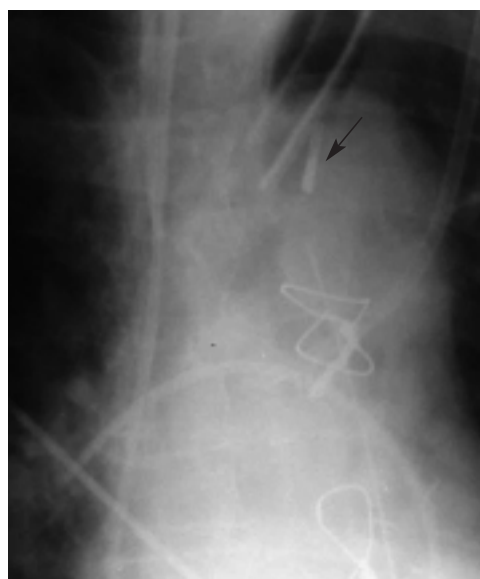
Plain chest X-ray repeated after minimal displacement of the intra-aortic balloon pump catheter. The catheter tip (black arrow) can now be easily recognized.
